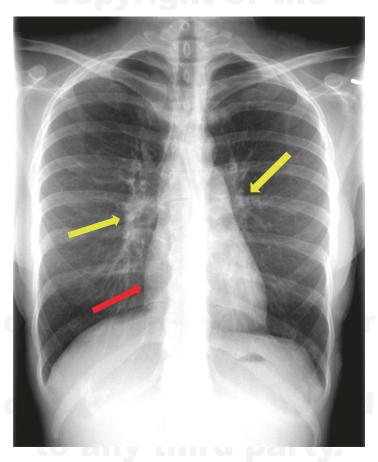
Chest X-ray shows a slightly enlarged right atrial silhouette (red arrow), prominent central right and left main pulmonary arteries (yellow arrows), and peripheral hypovascularity
